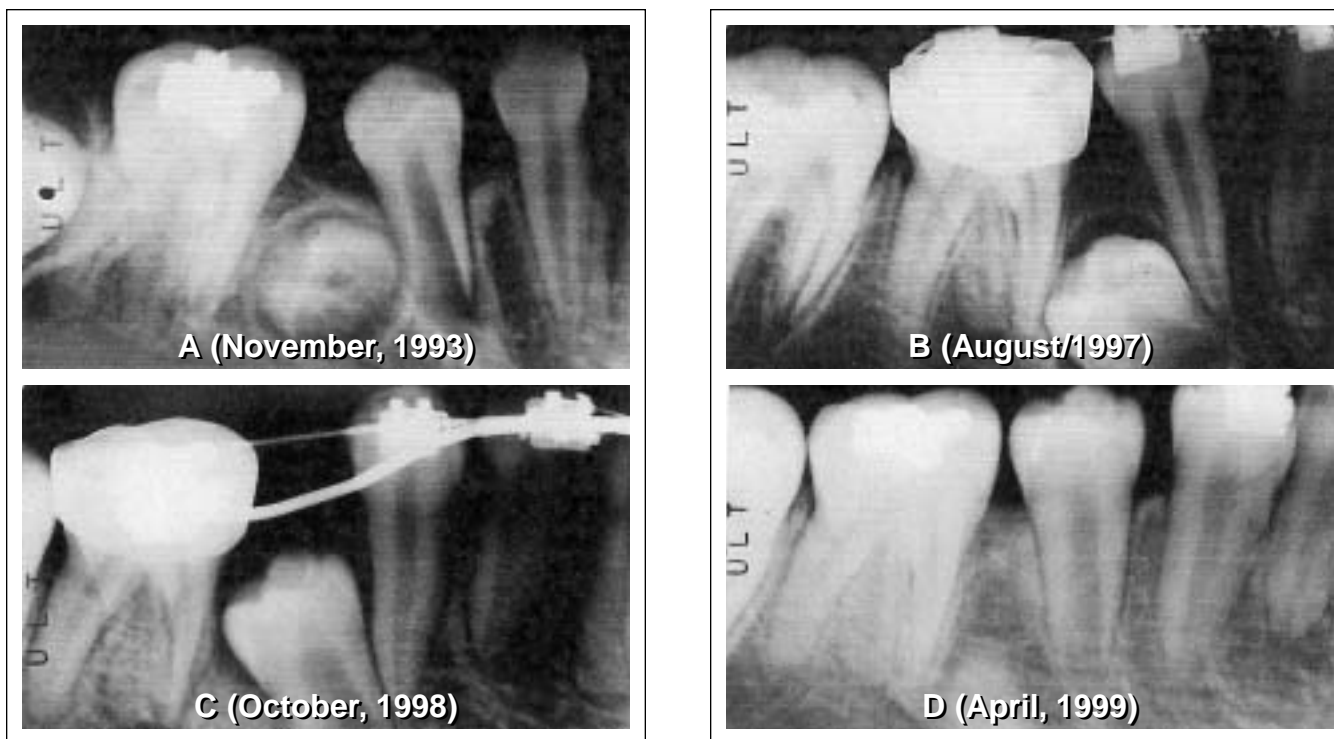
The longitudinal periapical radiographs show the complete development of the lower right second premolar, from tooth bud to full occlusion.
